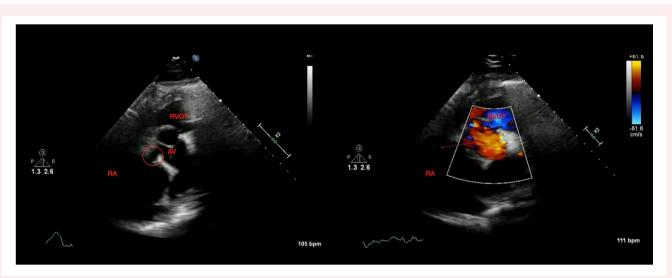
(A–B): A TTE parasternal short axis view at the level of the aortic valve showing the sinus of valsalva aneurysm (circled) (A). Doppler imaging (B) reveals the resolution of the regurgitant flow from the non-coronary sinus to the right atrium (arrow). AV, Aortic Valve; RA, Right Atrium; RVOT, Right Ventricular Outflow Tract.
